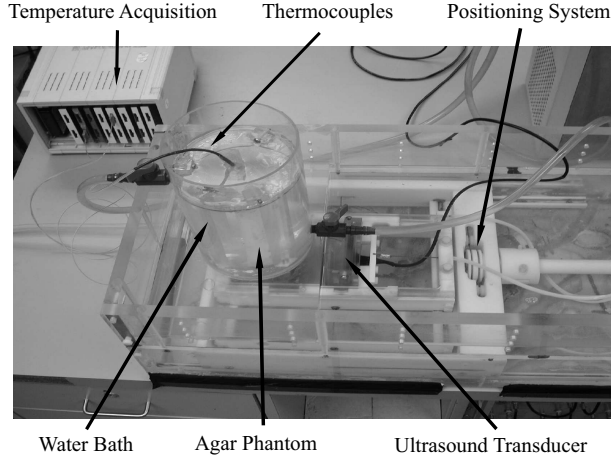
Ultrasound positioning and temperature acquisition system
